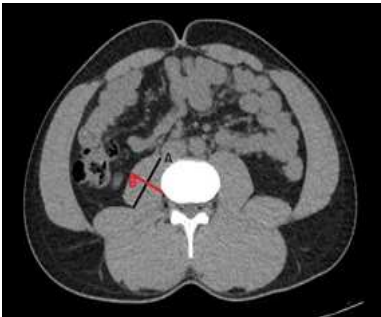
shows a computed tomography (CT) scan image with the right psoas muscle thickness measured at the L3 level. Psoas muscle thickness is equal to the transverse psoas muscle's diameter (red line,B) which is perpendicular to the axial diameter (black line,A)
